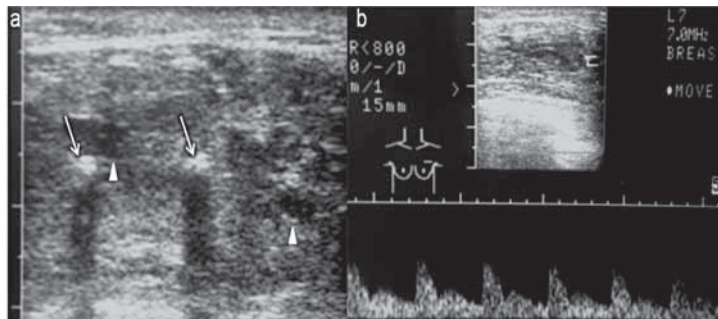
Gray-scale ultrasonography (a) depicted a heterogeneous hypoechoic mass with calcifications (arrows) and cystic areas (arrowheads), where arterial flow appeared on spectral analysis (b).
